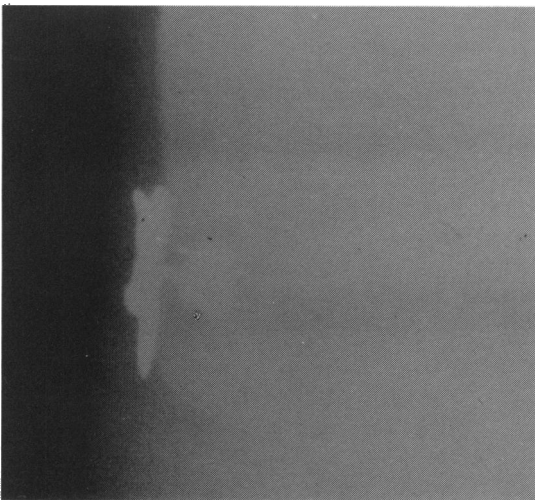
Figure Radiograph of ear of case 1 showing complete earring 'invisible' at examination of ear.
